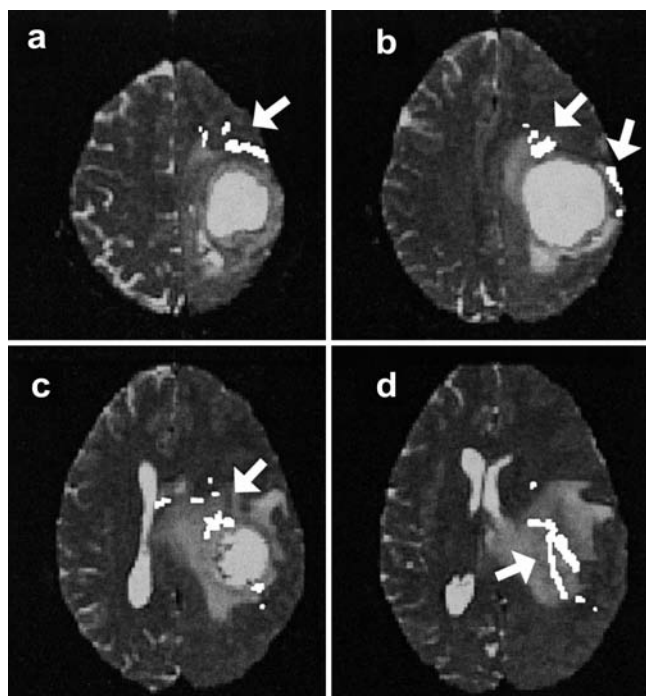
Case 2. Diffusion-tensor MR images demonstrating fiber track divergence in regions of edema. a: Fiber tracks (arrow) from a wrist/finger motor site initially descend through the precentral gyrus. b: Fiber tracks (arrows) descend parallel to the tumor border and enter a hyperintense region of edema (c). d: The tracks (arrow) are deviated posteriorly and are not consistent with the known location of the pyramidal tract at this level.
